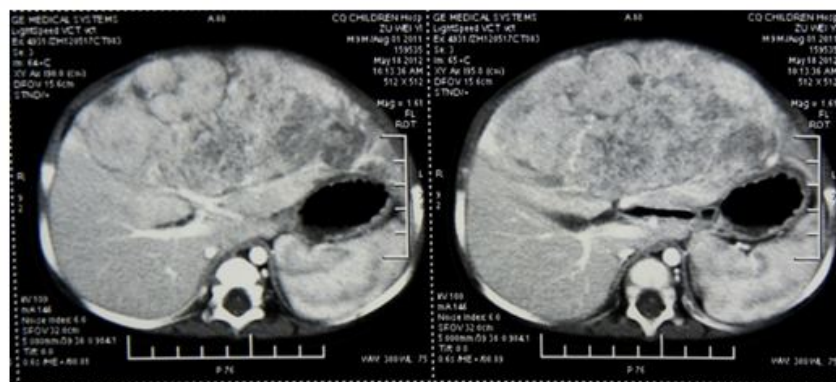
CT scan of a hepatoblastoma amenable to surgical resection.
